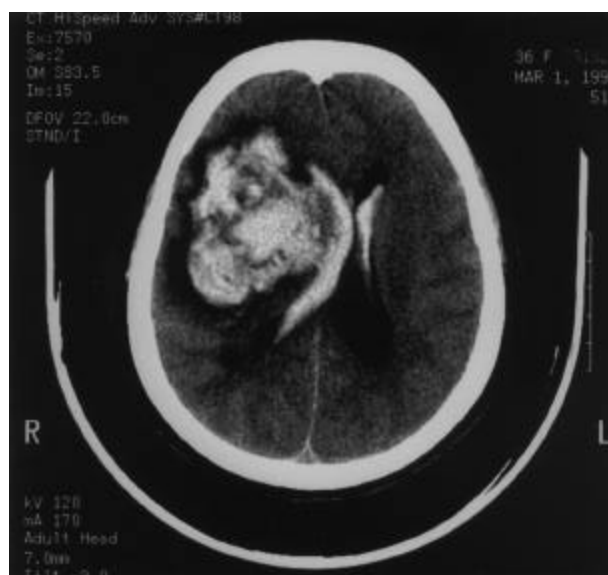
Non-contrast CT Brain showing a large right intracerebral haematoma with subfalcine herniation.
